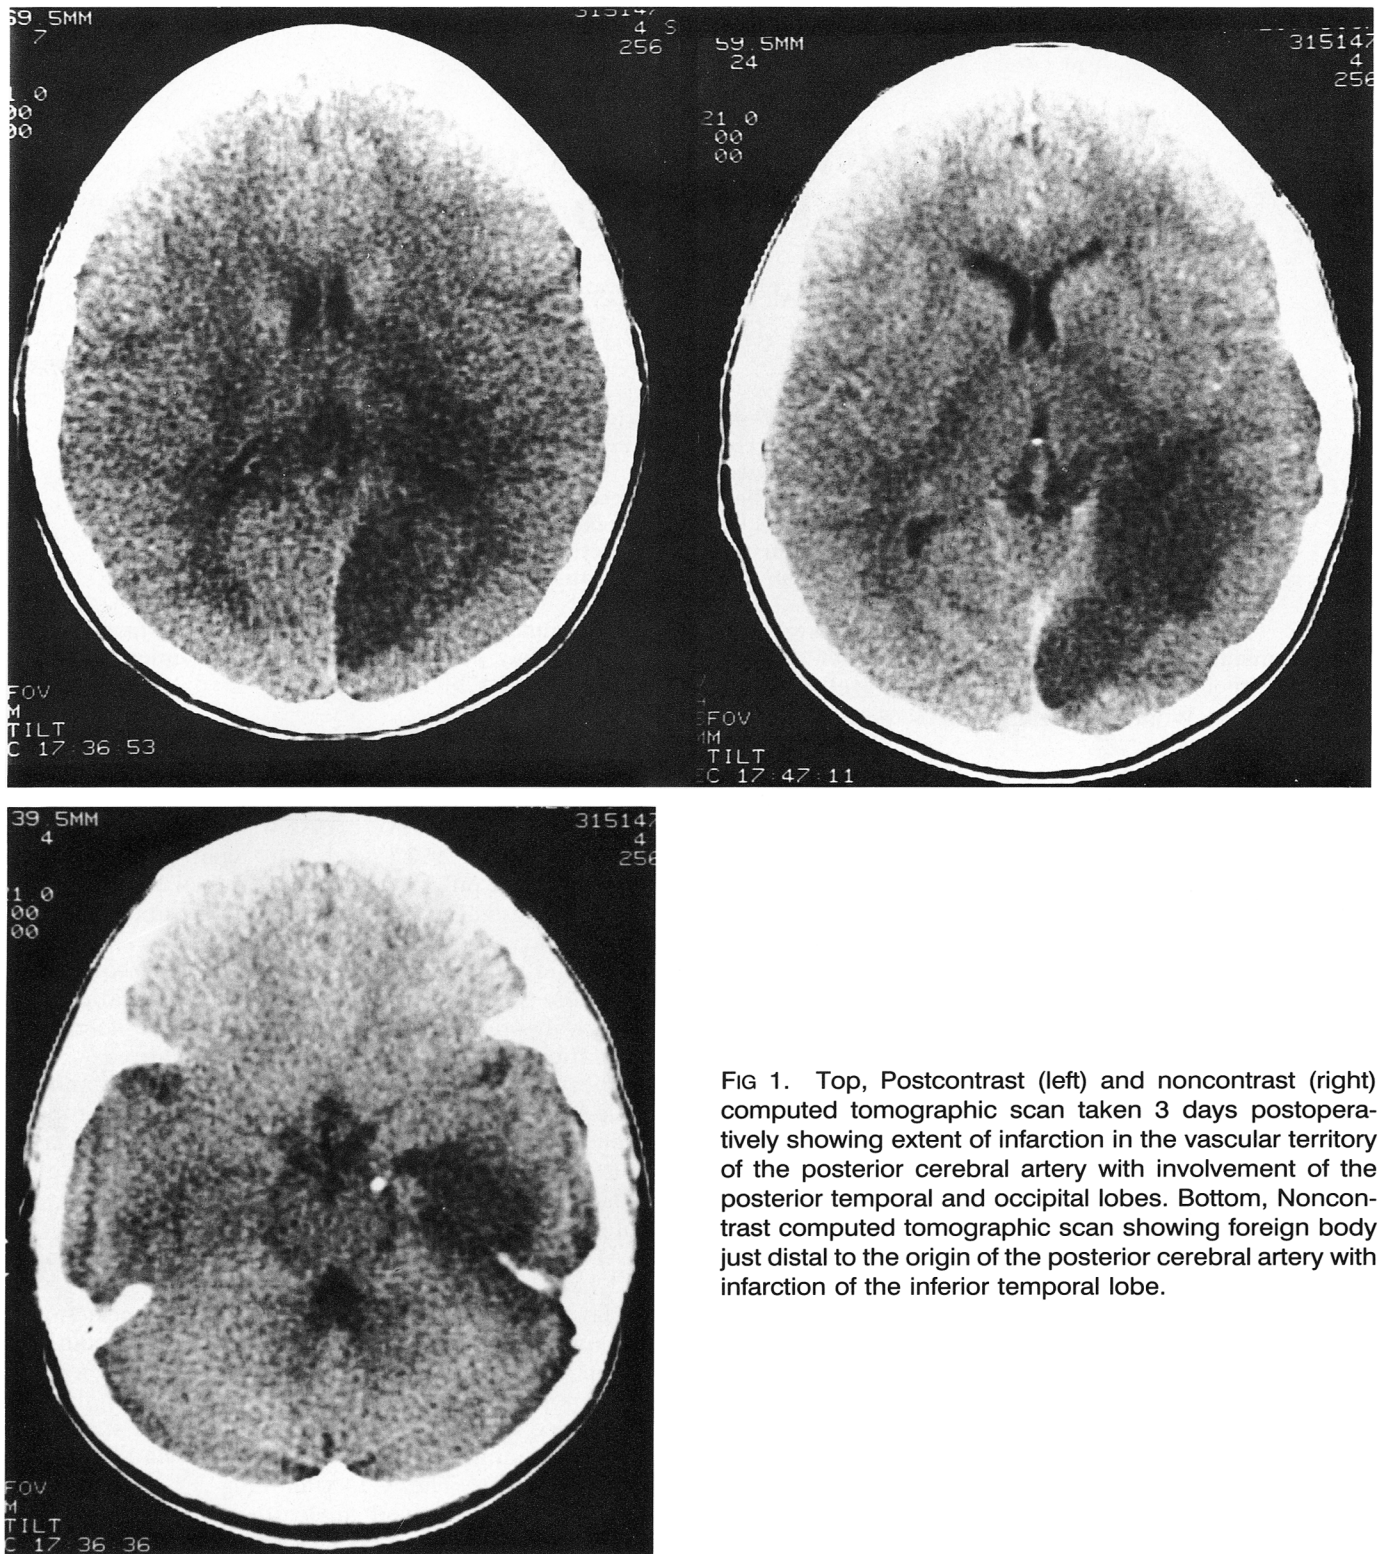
Top, Postcontrast (left) and noncontrast (right) computed tomographic scan taken 3 days postoperatively showing extent of infarction in the vascular territory of the posterior cerebral artery with involvement of the posterior temporal and occipital lobes. Bottom, Noncontrast computed tomographic scan showing foreign body just distal to the origin of the posterior cerebral artery with infarction of the inferior temporal lobe.
